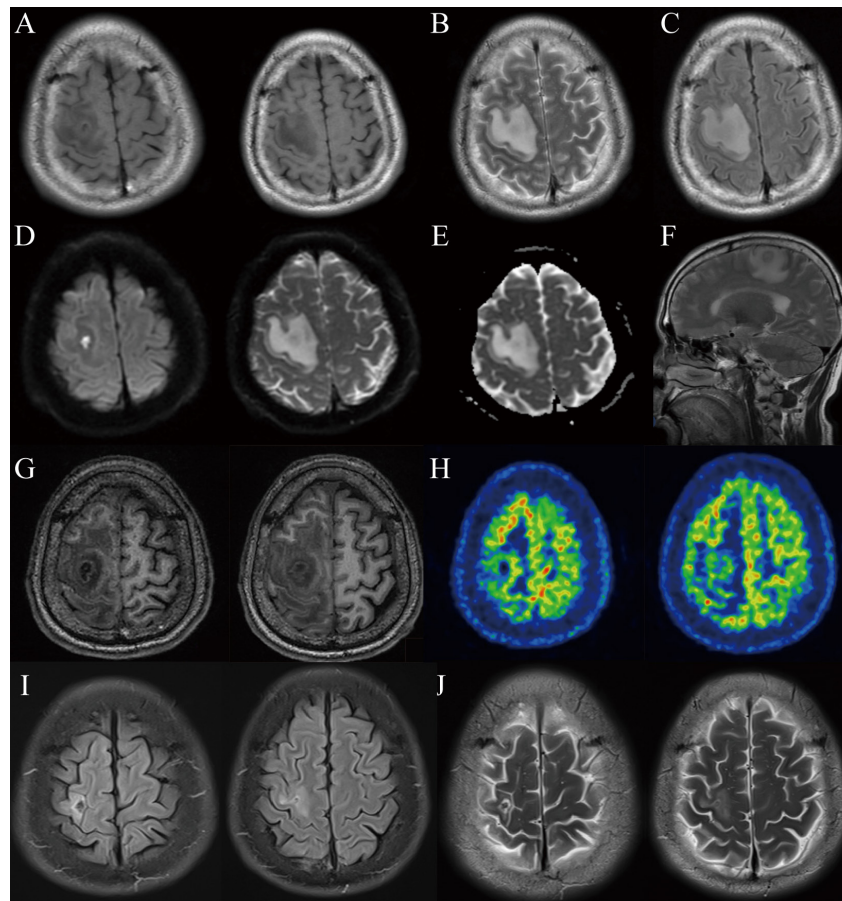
Imaging findings of the brain abscess. Initial brain MRI (A-F): Axial T1-weighted MR (A), T2-weighted MR (B), Flair MR (C), and sagittal T2-weighted MR (F) images show slightly long T1 and long T2 signal nodules in the right parietal lobe with inhomogeneous signals. Axial diffusion (D) with corresponding apparent diffusion coefficient (E) shows diffusion restriction of the right parietal lesion. Brain PET-CT on Day 5 (G-H): Axial PET-CT scans show a circular nodule in the right parietal lobe, with a clear boundary and a smooth inner margin. Brain MRI at 8 months (I-J): Axial T1-weighted MR (I) and T2-weighted MR (J) images show an elliptical-like abnormal signal shadow in the right frontal lobe.
